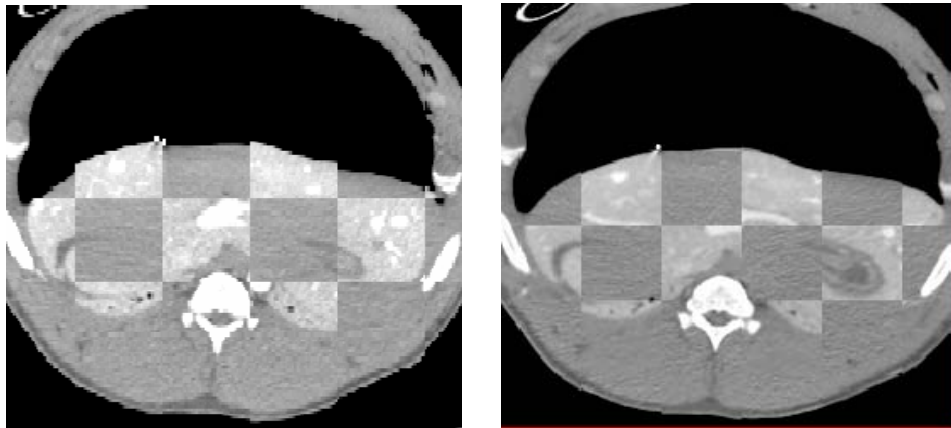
Superposition of initial CT and intra-operative CT (acquired at 200 mAs) before (left) and after (right) nonrigid registration. Note better structure alignment after registration.
